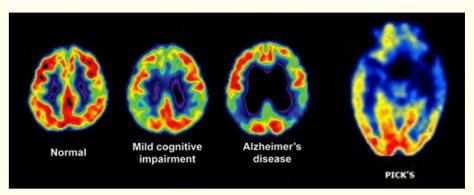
Normal FDG-PET CT, mild cognitive impairment, AD, and bvFTD.
